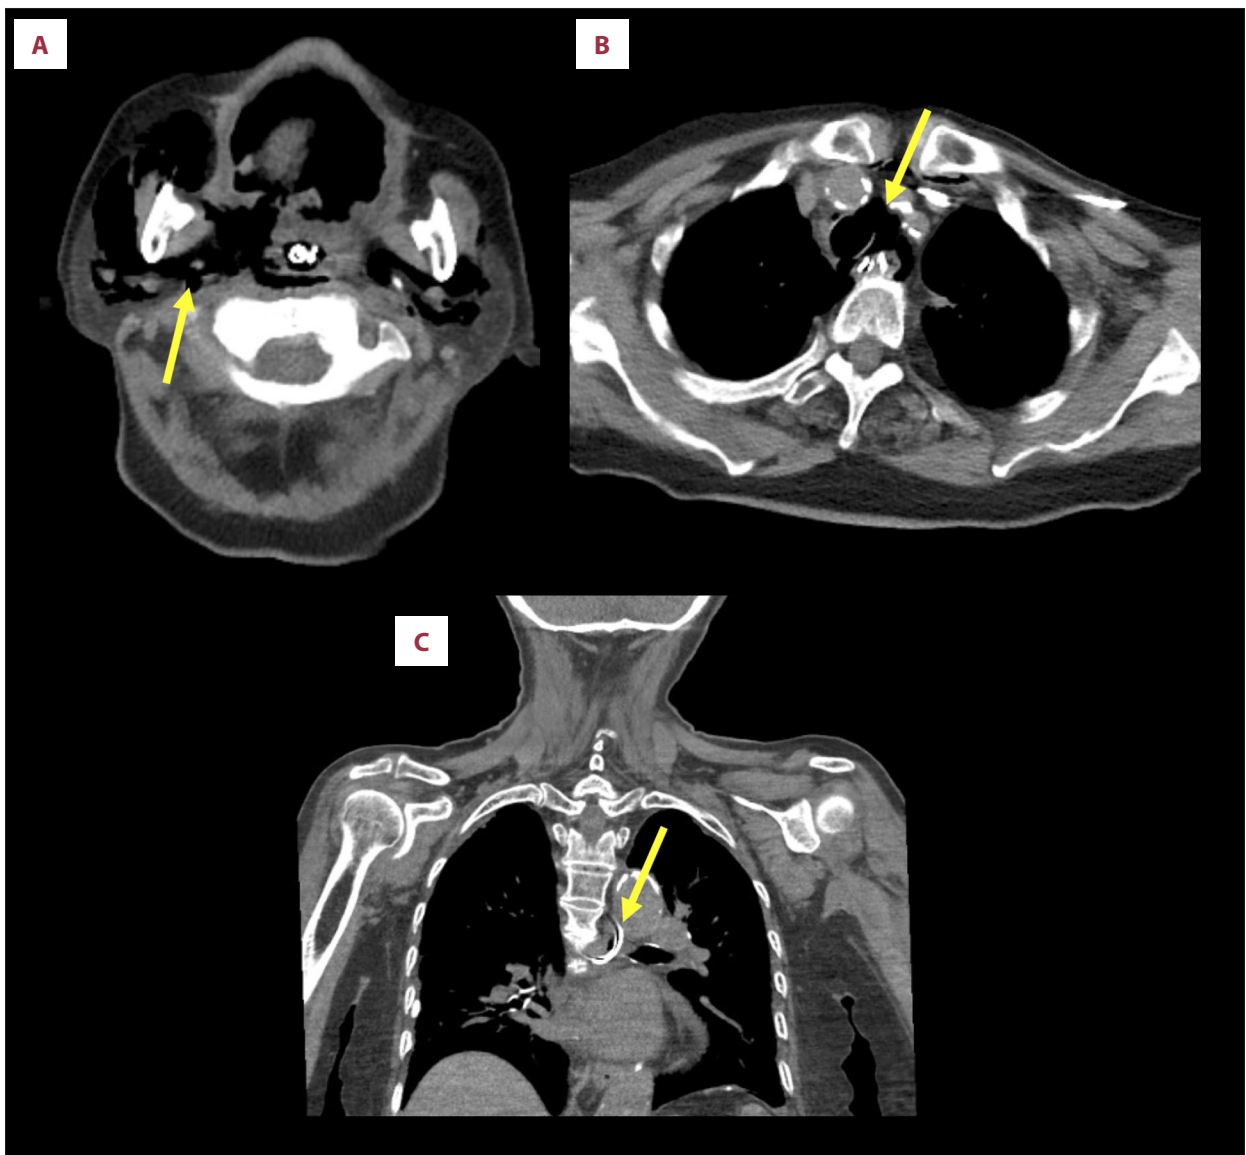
(A) Computed tomography (CT) scan shows cervical emphysema and the distal end of the NGT in the nasopharynx (arrow). (B) CT scan shows pneumomediastinum (arrow). (C) CT scan shows the bent NGT at the esophagus (arrow).
